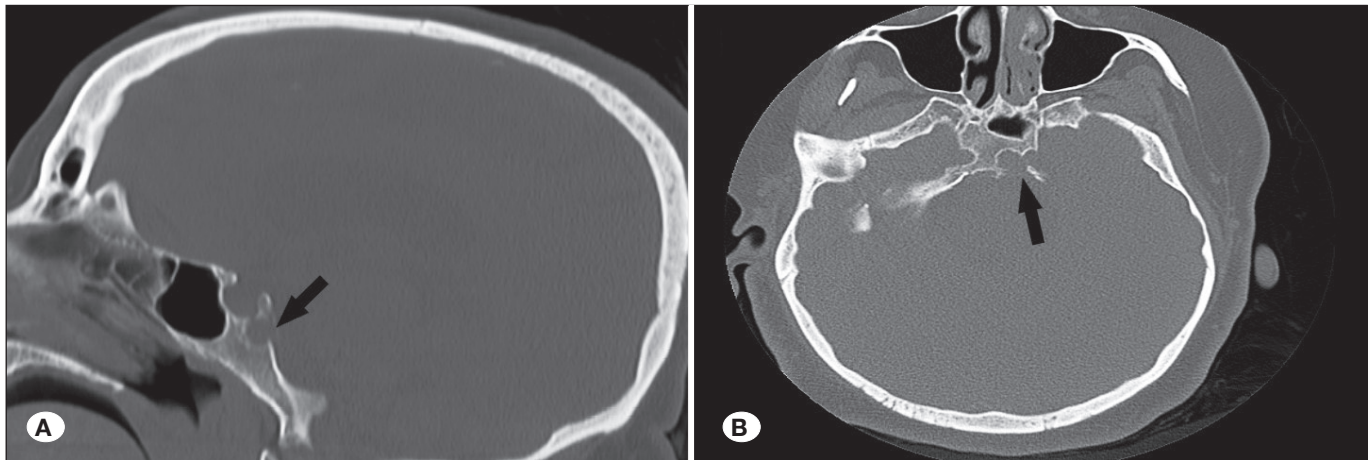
Preoperative sagittal computerized tomography (CT) scan of a representative patient. A) Sagittal and B) Axial CT images (black arrows shows bone changes).
